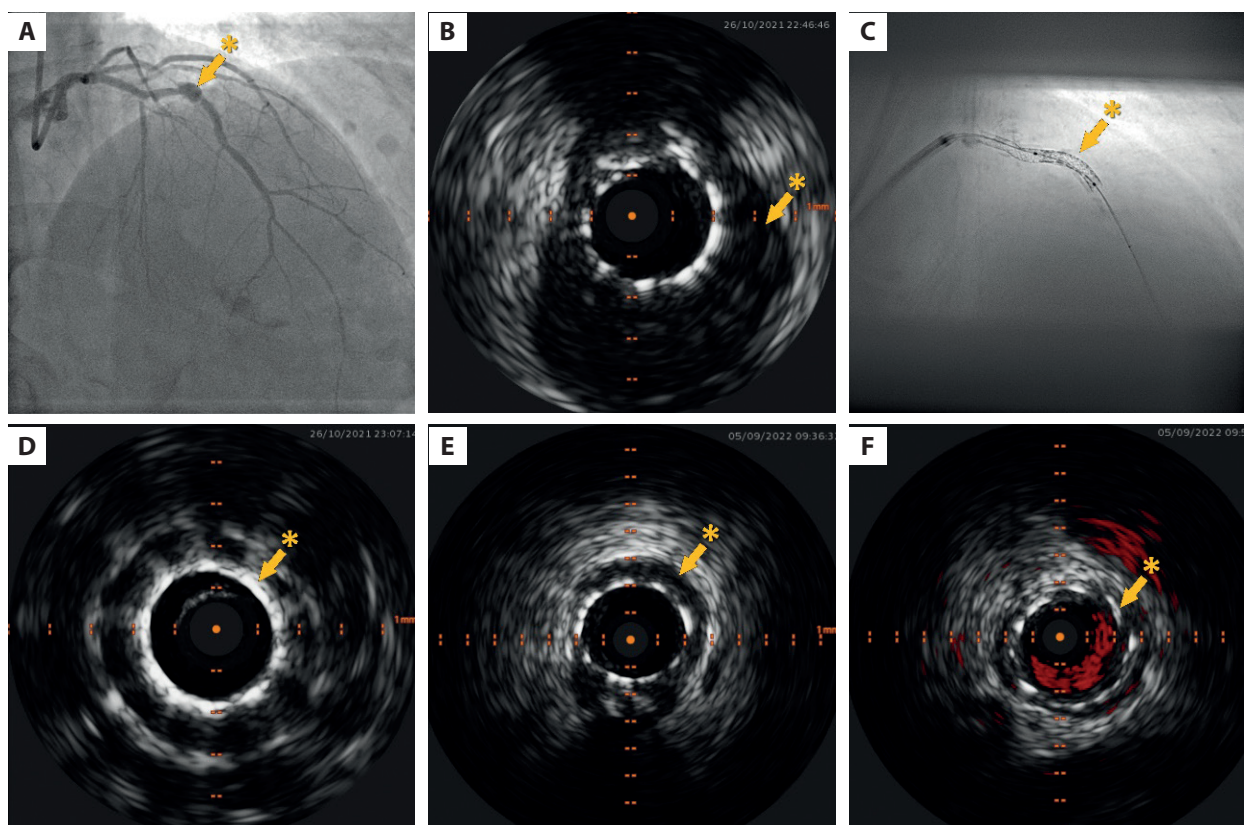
A. Angiography: a coronary artery aneurysm (CAA) (*) in the medial left anterior descending artery (LAD). B. Intravascular ultrasound (IVUS) imaging of the CAA (*). C. ClearStent view of the medial LAD after covered stent placement (*). D. IVUS imaging of the covered stent in the CAA (*). E. IVUS imaging of the covered stent — suboptimal stent expansion (*). F. IVUS imaging of the covered stent after optimization (*)
